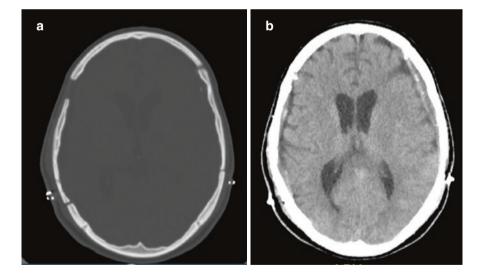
CT scan at 2 months follows up. (a) Bone window setting showing replacement of bilateral bone flaps. (b) Brain setting showing resolved edema, and minor subdural hygromas
